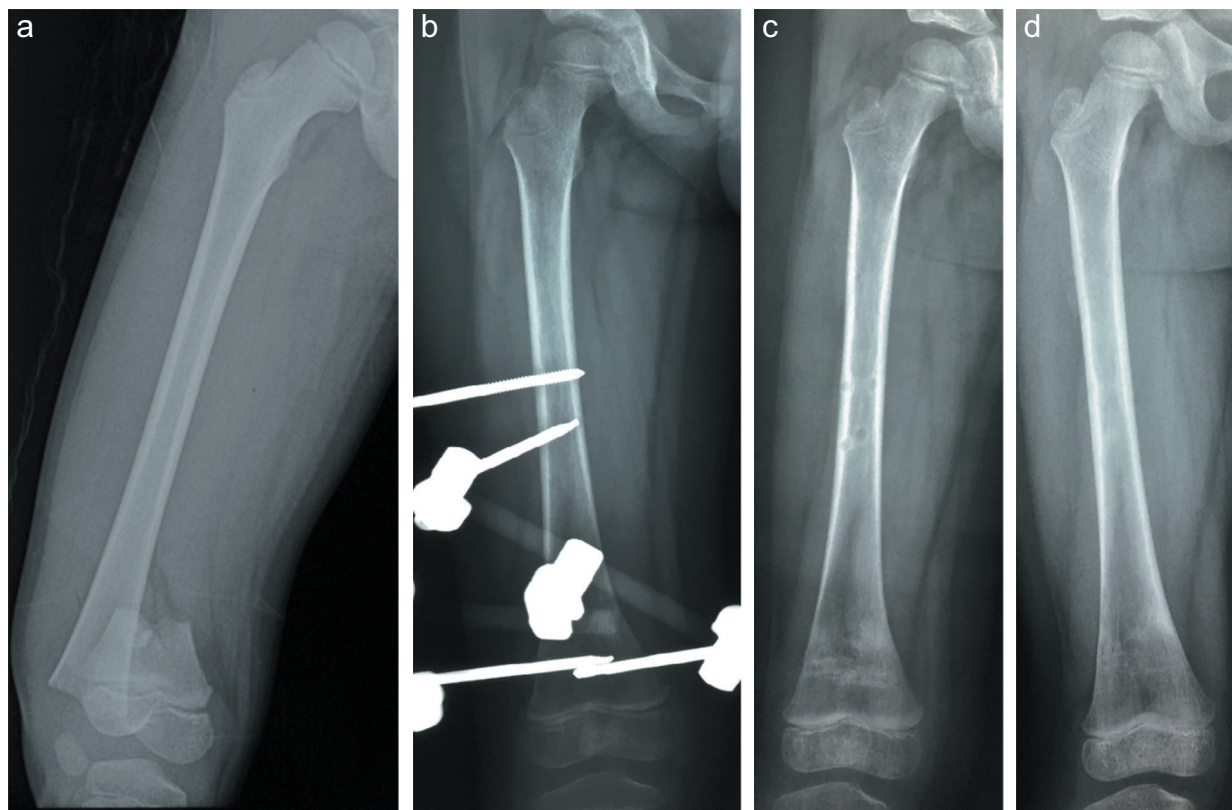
a-d. (a) X-ray AP view of knee with femur right side showing supracondylar femoral fracture in a 5.8-year-old female. (b) X-ray AP view of the same patient 2 months postoperative with external fixation. (c) X-ray AP view of the same patient 3 months postoperative, external fixation removed for one month. (d) X-ray AP view of the same patient 18 months postoperative.
